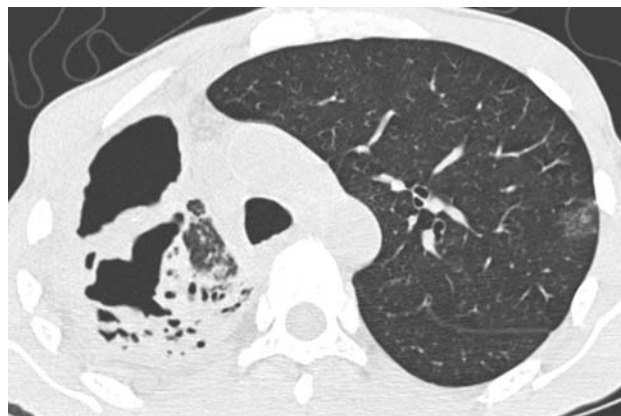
Computed tomography scan showing area of consolidation with a new cavitation in the right upper lobe.
